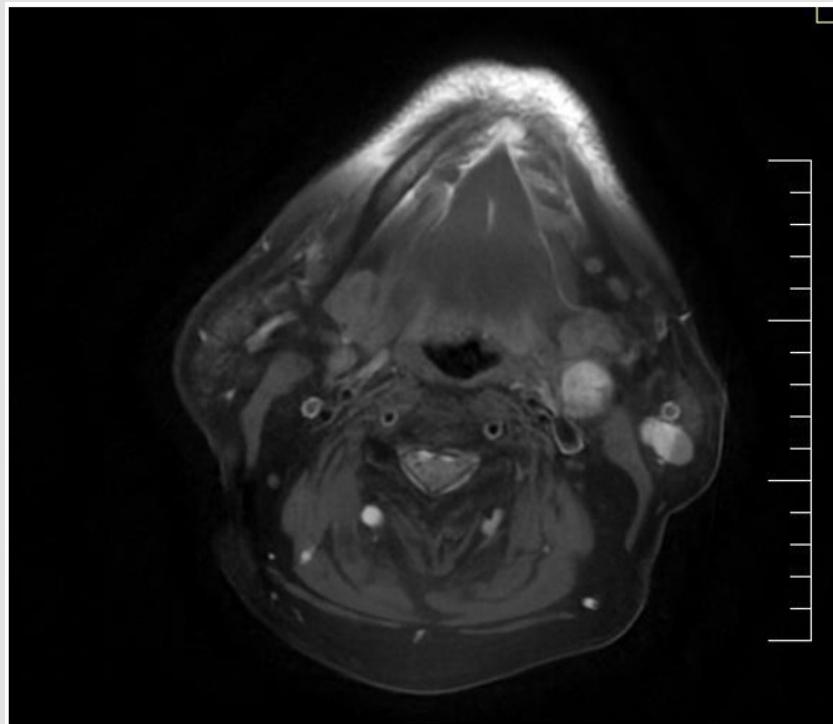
Axial MRI images demonstrate a left level IIa laterocervical lymphadenopathy, round shape, with a short-axis diameter of 17 mm and heterogeneous internal structure, showing areas of T1 fat-saturated hyperintensity. The imaging features are suspicious for malignancy.
